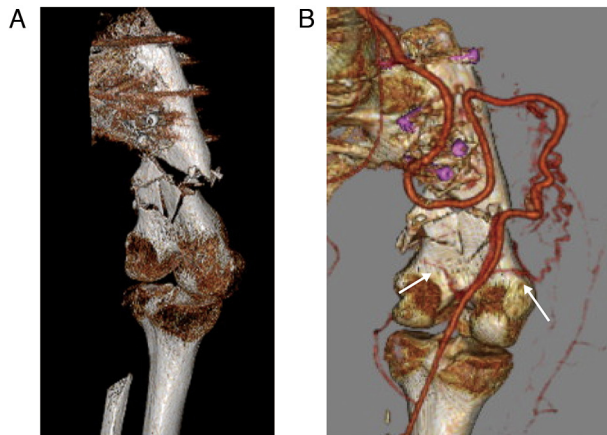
Preoperative computed tomographs. (A) CT showed similar observations as preoperative radiograph for restructured bone distally. (B) Inflow of blood vessels (arrows) into the distal fracture fragment is confirmed by angio-CT. CT, computed tomography.
